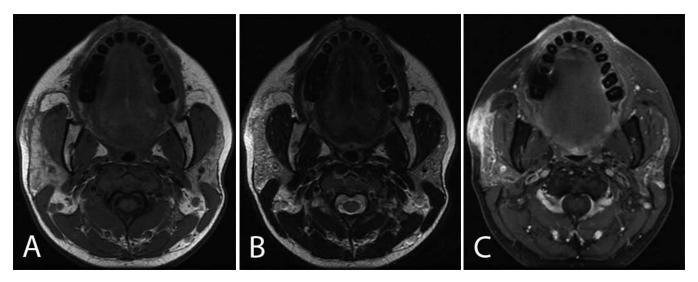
41-year-old female with lupus erythematosus panniculitis. A. Axial MRI T1 without contrast image at the level of the right accessory parotid shows an ill-defined reticulated lesion involving the accessory right parotid gland, with extension into adjacent subcutaneous fat. B. Axial MRI T2 image shows high signal intensity in the right peripartoid fat. The right parotid itself does not appear hyperintense. C. Axial MRI T1 postcontrast, fat-saturated image shows high signal intensity and marked homogeneous enhancement in the right accessory parotid, with extension into the adjacent subcutaneous fat.
